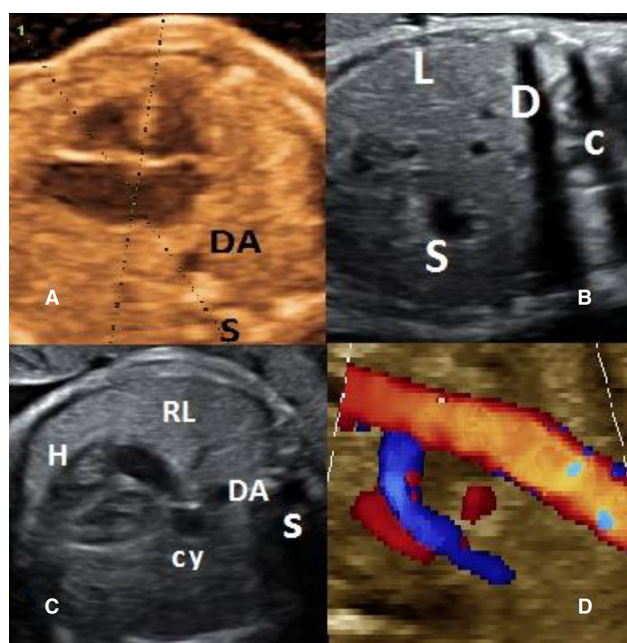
Antenatal ultrasound a Four chamber view (axial section) at 22 week, b stomach seen at normal position at 32 week, c four chamber view at 32 week, d upturn course of superior mesenteric artery at 32 week. C Chest; cy Cyst; D Diaphragm; DA Descending aorta; H Heart; L Liver; RL Right lung; S Spine
